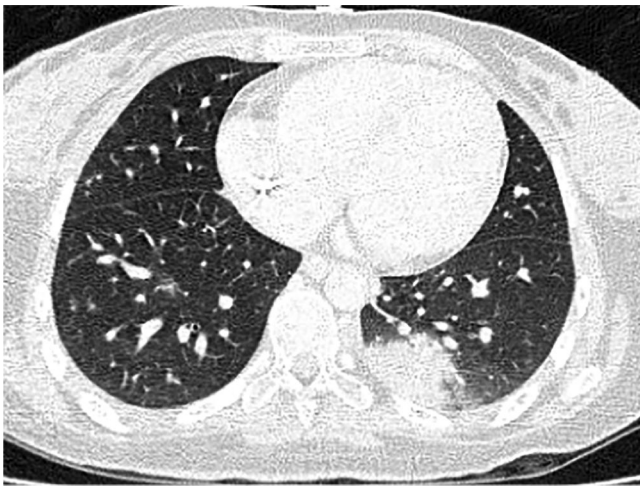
Chest computed tomography showing a large nodule with a halo sign in the left lung.
